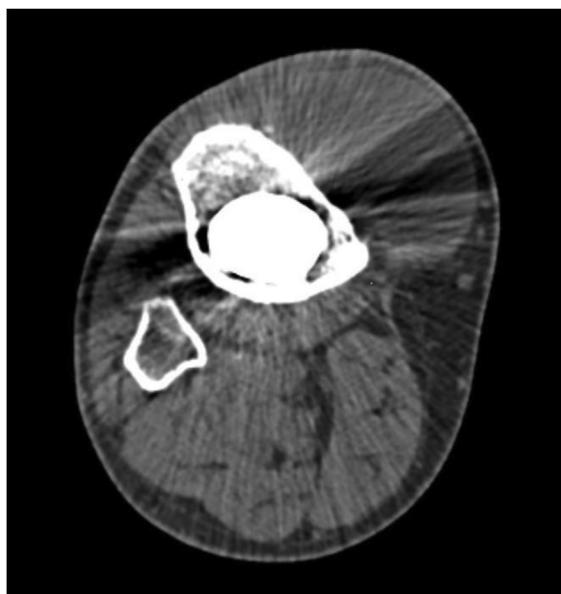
Axial cut of CT scan of the right knee, which demonstrates the soft tissue mass observed at patient's medial tibial plateau.
